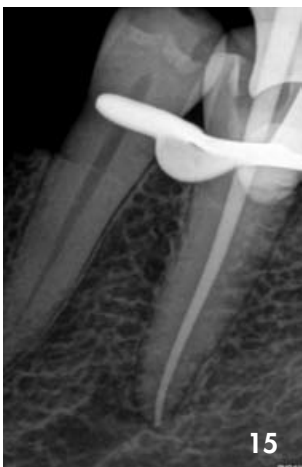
Cone-fit periapical radiograph.
